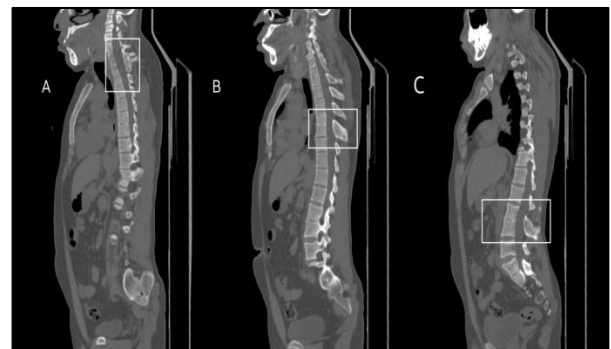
Plain CT whole spine bone window (Sagittal sections) showing multiple fused vertebral bodies and their posterior elements in lower cervical, upper dorsal, lower dorsal and in lumbar spine (white boxes). (A) Fused vertebral bodies and posterior elements of C5 till D3. (B) Partially fused vertebral bodies and fused posterior elements of D8, D9. (C) Partially fused vertebral bodies and fused posterior elements of L2, L3.
